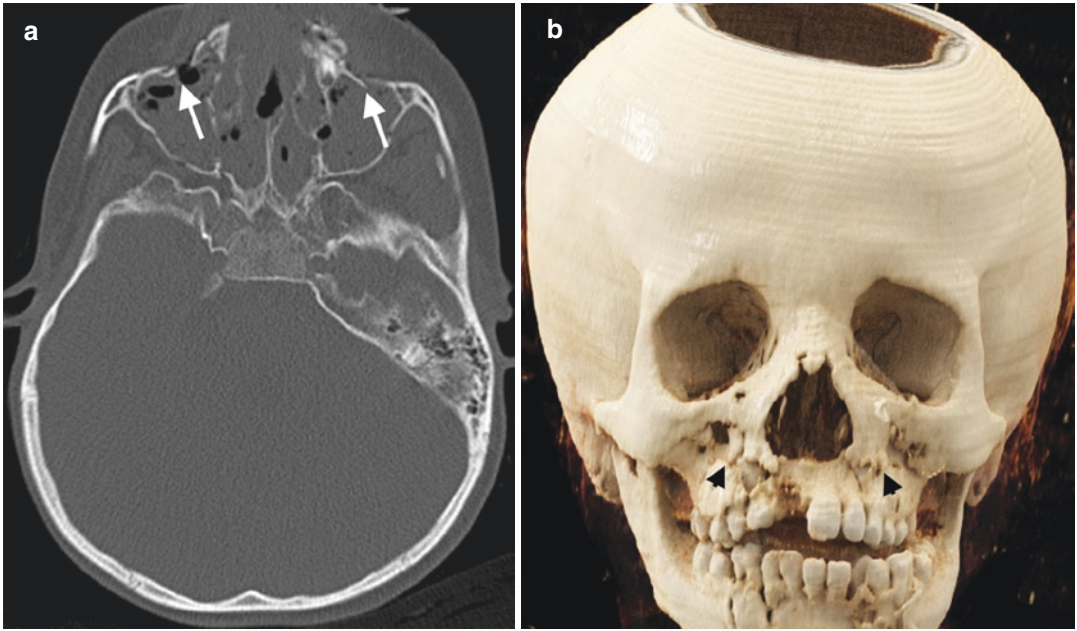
Le Fort I fracture. (a) Axial CT image shows bilateral anterior maxillary sinus wall fractures (arrow). (b) CR image demonstrates Le Fort I fracture (black arrowheads) extending through superior to the maxillary alveolar process
